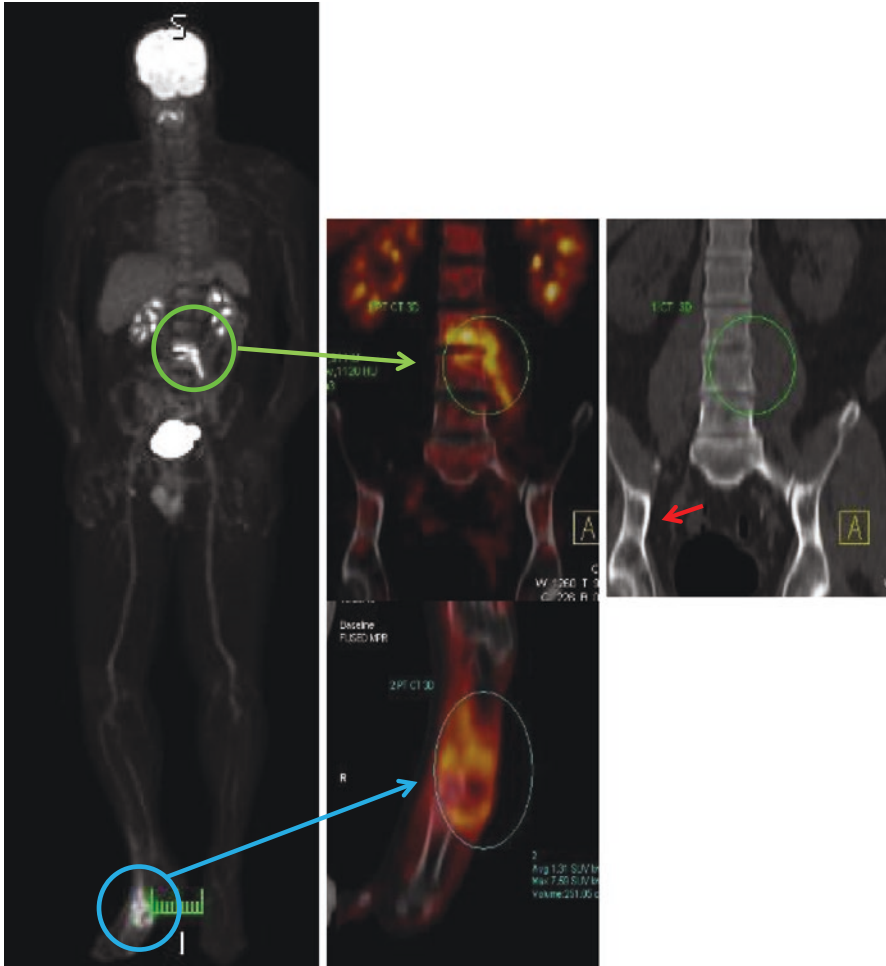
All diskitis is not TB: 42y M with previous history of treated TB, with right foot cellulitis treated with antibiotics, but persistent fever, normal CT chest & abdomen. A FDG PET CT shows right mid-foot diffuse bone and soft tissue tracer uptake and L3/4 lumbar disko-vertebral activity with left sided para-vertebral activity in the left psoas muscle. CT abnormalities at L3/4 end plate are subtle. Tubercular diskitis was suspected on account of the previous history. CT guided L3/4 aspiration grew staphylococcus aureus with no mycobacterial growth and complete resolution following a prolonged course of antibiotics. TB diskitis and pyogenic diskitis can have similar features, so tissue diagnosis is vital
